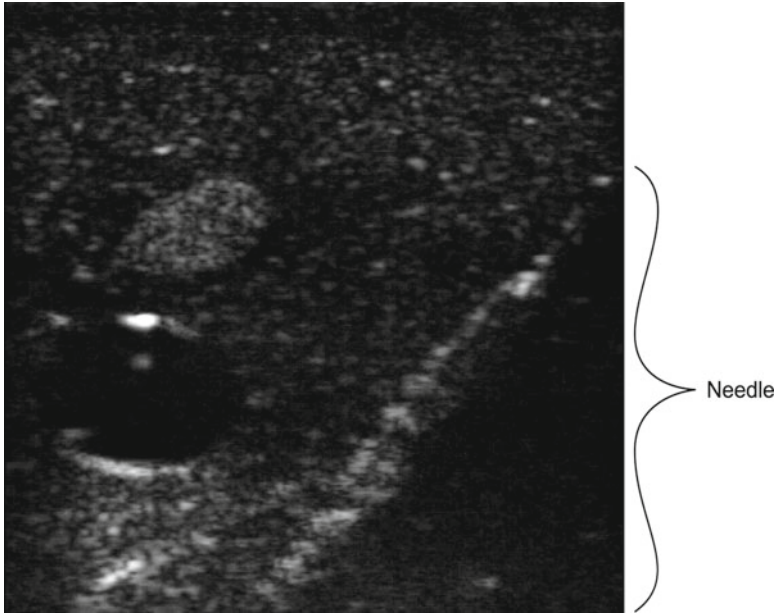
Reflection of the ultrasound beam from a needle at 45° of insonation
